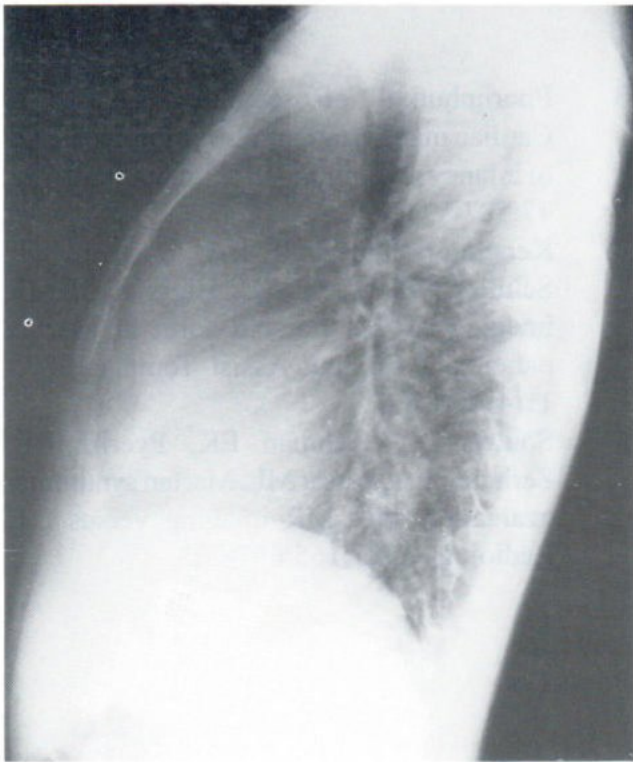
Lateral chest radiograph shows obliteration of the retrosternal clear space by the dilated ascending thoracic aorta.
